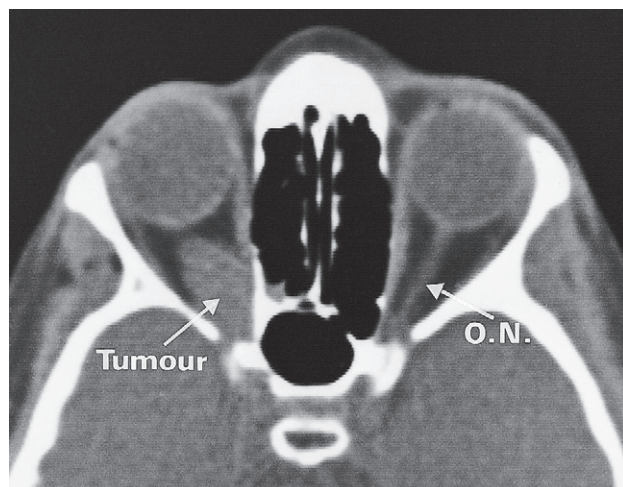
Optic nerve glioma. CT scan showing a soft tissue mass arising from the optic nerve (O.N.). The opposite orbit demonstrates the normal anatomy.
